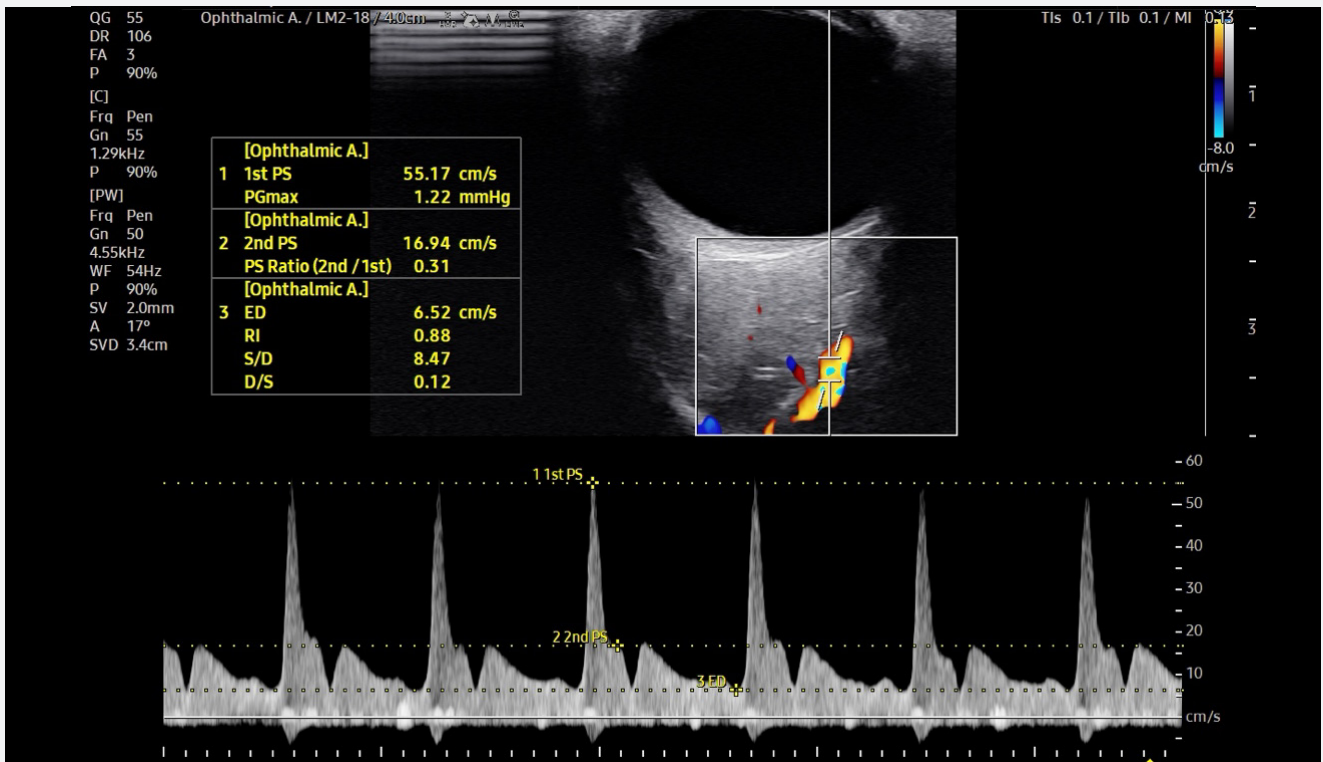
Doppler waveform with manual placement of first PS, second PS and EDV with calculation of the PS Ratio and RI
